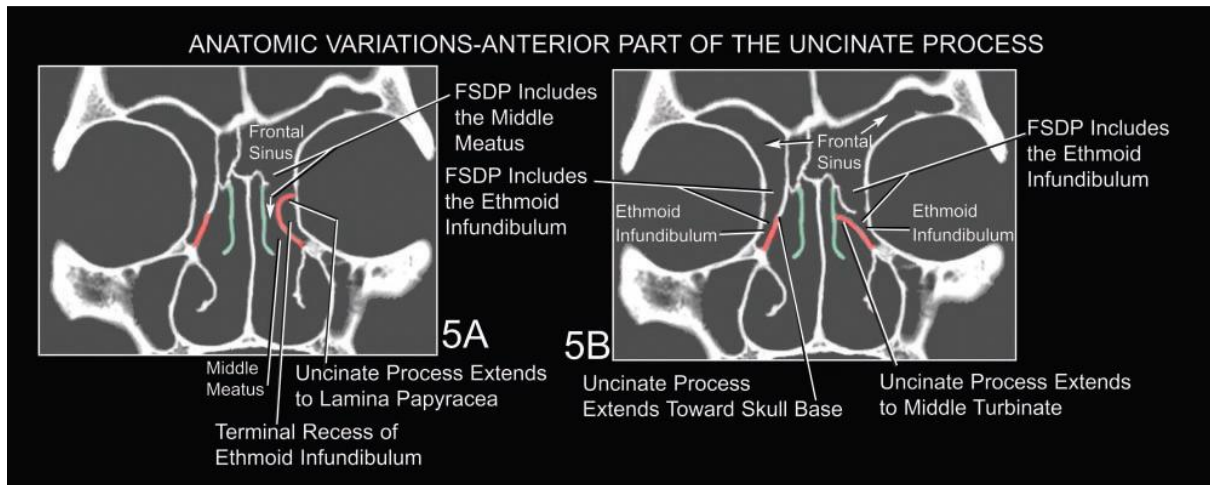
Anatomic variations of SAUP on coronal CT scan sections and its effect on FSDP (5A & B). Courtesy of Daniels,2003(9)
